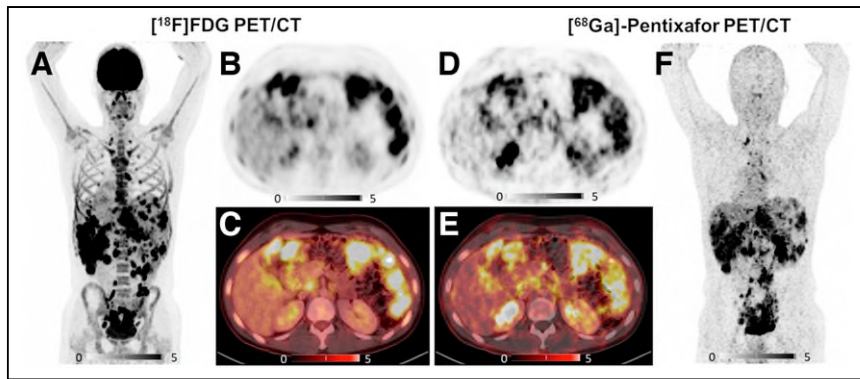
PET/CT scans with [^{68}Ga]pentixafor and [^{18}F]FDG for patient 2. (A–C) [^{18}F]FDG PET/CT shows intensive uptake in all tumor lesions (abdominal primary, lymph node, and hepatic metastasis) and moderate reactive uptake in bone marrow caused by chemotherapy. (D–F) In comparison, [^{68}Ga]pentixafor PET/CT demonstrates intensive and specific tracer accumulation in tumor lesions.
